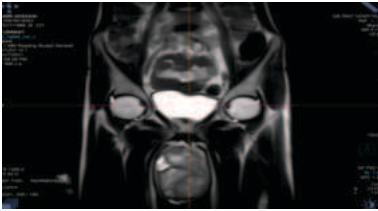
(a) MRI Of Scrotum – Coronal Section Showing The Multinodular tumour
